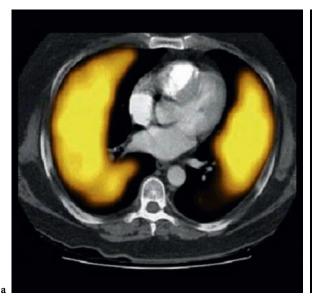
Fused CTPA-perfusion SPECT of the transverse (a) and sagittal (b) views in a 48-year-old male demonstrating left lower lobe apical and posterobasal segmental defects. An additional perfusion defect is also seen in the apico-posterior segment of the upper lobe. The patient was diagnosed as having suffered pulmonary embolism despite no filling defects being seen on CTPA. (Courtesy of HARRIS et al. 2007)
